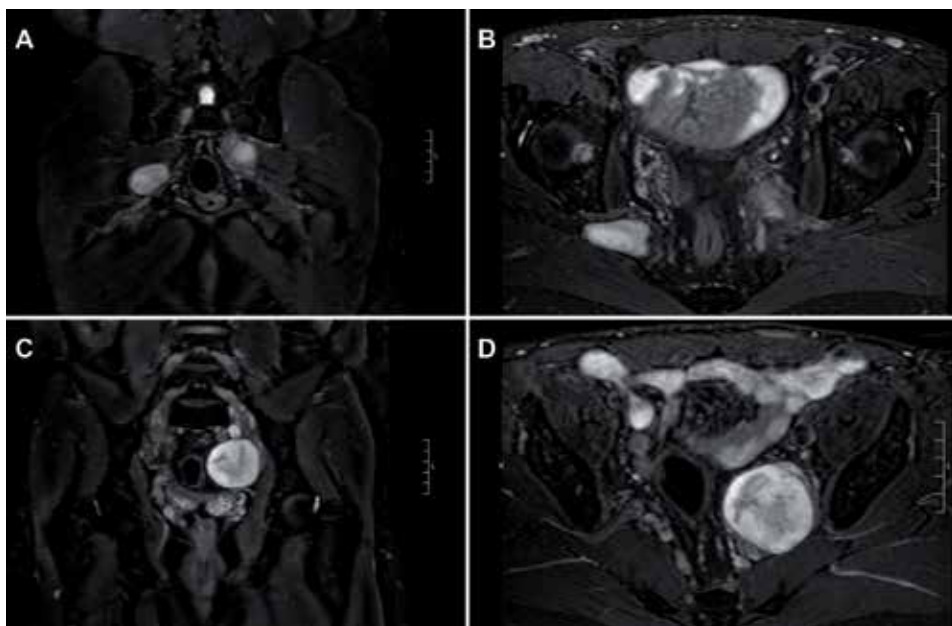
(A) T2 weighted MRI, coronal section; (B) T2 weighted MRI, axial section; (C) T2 weighted MRI, coronal section; and (D) T2 weighted MRI, axial section. Large round nerve sheath tumor of the sciatic nerve at the sciatic notch (panels A and B), and large left nerve sheath tumor in the left hemi-pelvis, arising from the inferior aspect of the left L5 nerve root (panels C and D).
